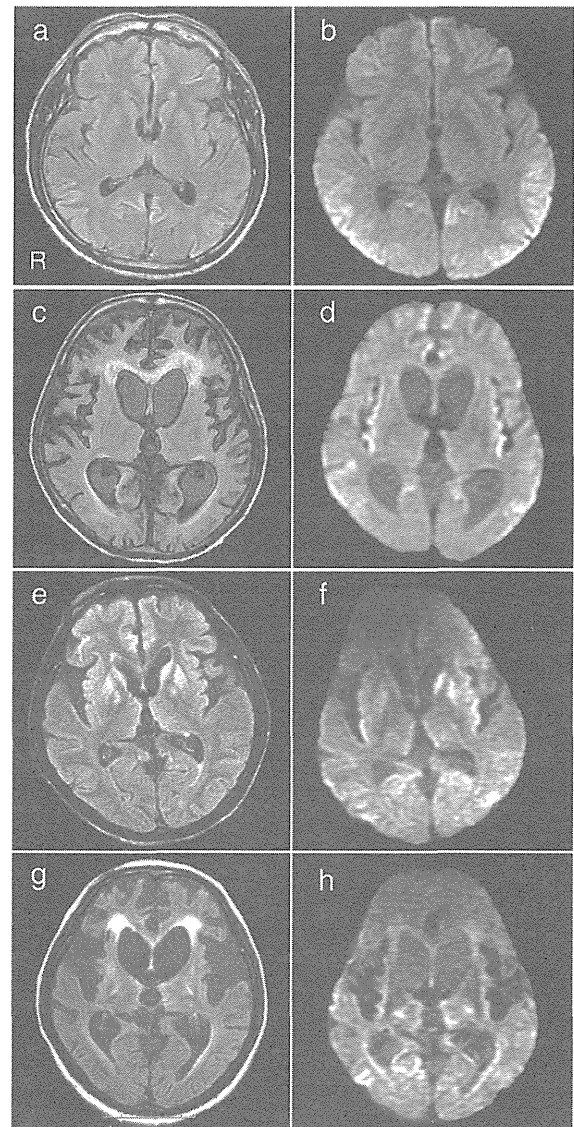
Brain MR imaging (MRI); fluid-attenuated inversion recovery (FLAIR) and diffusion weighted images (DWI). (a,c,e,g) FLAIR images, (b,d,f,h) DWI. (a–d) Case 1. (a, b) Brain MRI at 6 months after onset shows no obvious brain atrophy, but revealed increased signal intensity in the bilateral temporal and parietal cortices, and to a lesser degree, in the frontal and occipital cortices. (c,d) Brain MRI at 9 months after onset shows marked cortical atrophy and dilation of both lateral ventricles. Additionally, periventricular hyperintensity on FLAIR images and increased signal in bilateral insular cortices on DWI are also noted. (e–h) Case 2 (e,f) A FLAIR image at 13 months after onset shows increased signal intensity in the bilateral frontal and insular cortices, striatum, pallidum, and thalamus on FLAIR. In addition, in DWI, increased signal in bilateral temporal, parietal, and occipital cortices is noted. (g,h) Brain MRI at 23 months after onset shows marked atrophy in the neocortex and basal ganglia. Marked dilation of the both lateral ventricles and periventricular hyperintensity are also noted.
